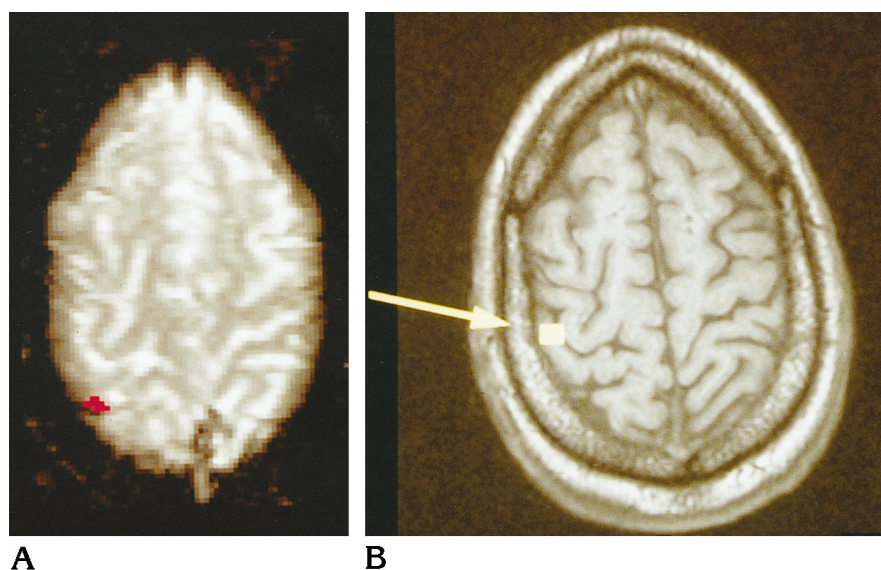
Left index finger stimulation: functional MR imaging (A) and magnetic source imaging (B). Pixels identified as activated by functional MR imaging are overlaid on an acquired gradient-echo echo-planar image (echo time, 60; flip angle, 90°; FOV, 40 × 20 cm, matrix, 128 × 128). Magnetic source imaging locations are overlaid on a spoiled gradient-echo MR image (35/5) (flip, 30°; section thickness, 1.5 mm). Both techniques show agreement on the superior level of somatosensory digit representation in this subject.
